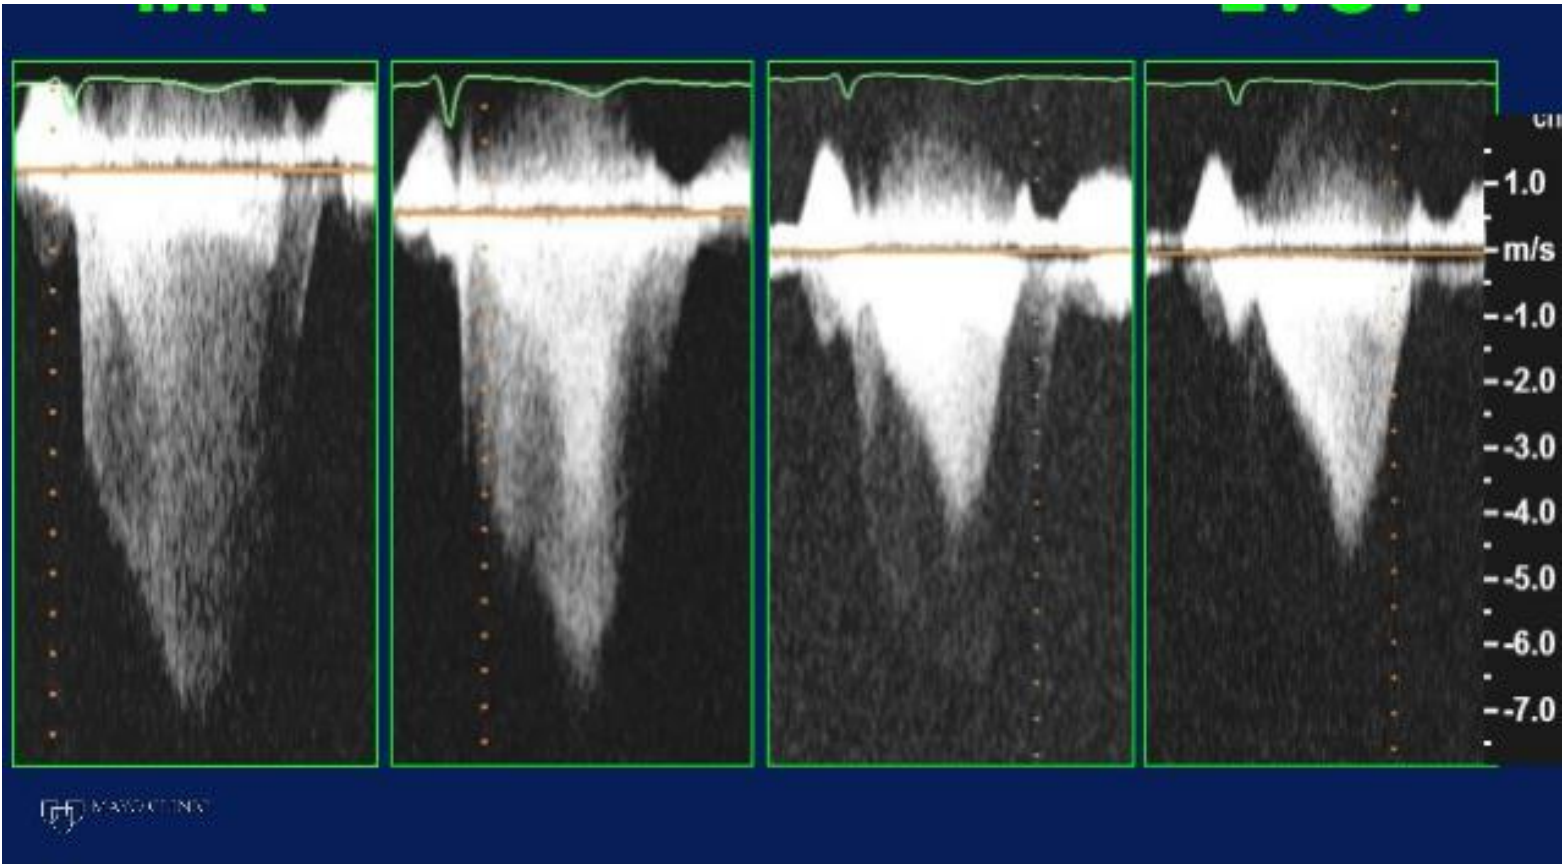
Continuous-wave (CW) Doppler recordings of peak velocity across the LVOT (*cross*: 4.5 m/sec) (*left*) and peak velocity of mitral regurgitation signal (*arrow*: 6.3 m/sec) (*right*). The concave-to-the-left contour of the Doppler CW jet causes a decrease in the LVOT orifice size as systole progresses and as the mitral valve is pushed further into the septum. Identification of this contour can be useful to differentiate high CW jets of dynamic LVOT obstruction from mitral regurgitation and from valvular aortic stenosis.
